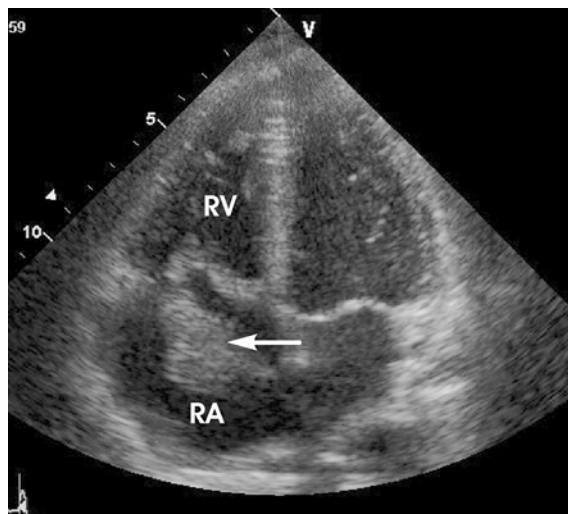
Detection of endocarditis in an ICU patient. Apical four chamber view showing vegetation on the tricuspid valve leaflet (arrow).
